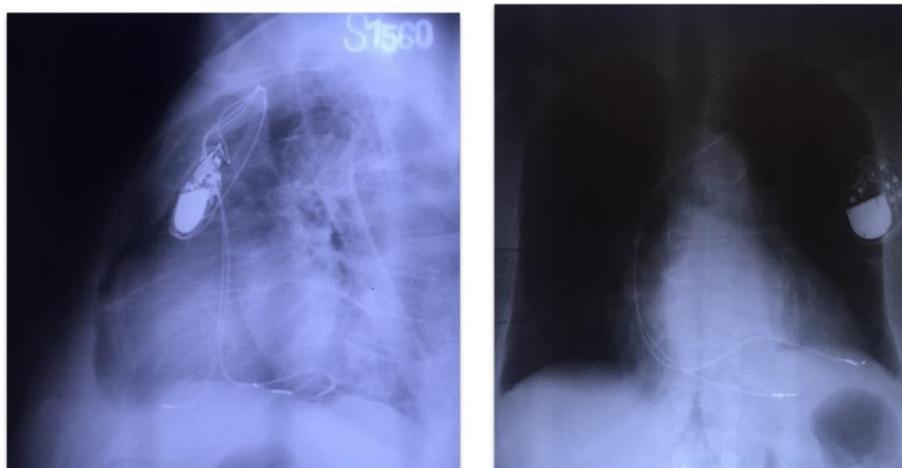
Thoracic X-ray, left lateral and posterior-anterior views. Dual chamber pacemaker with a lead placed in the right ventricular apex and a lead in a posterior vein via coronary sinus
